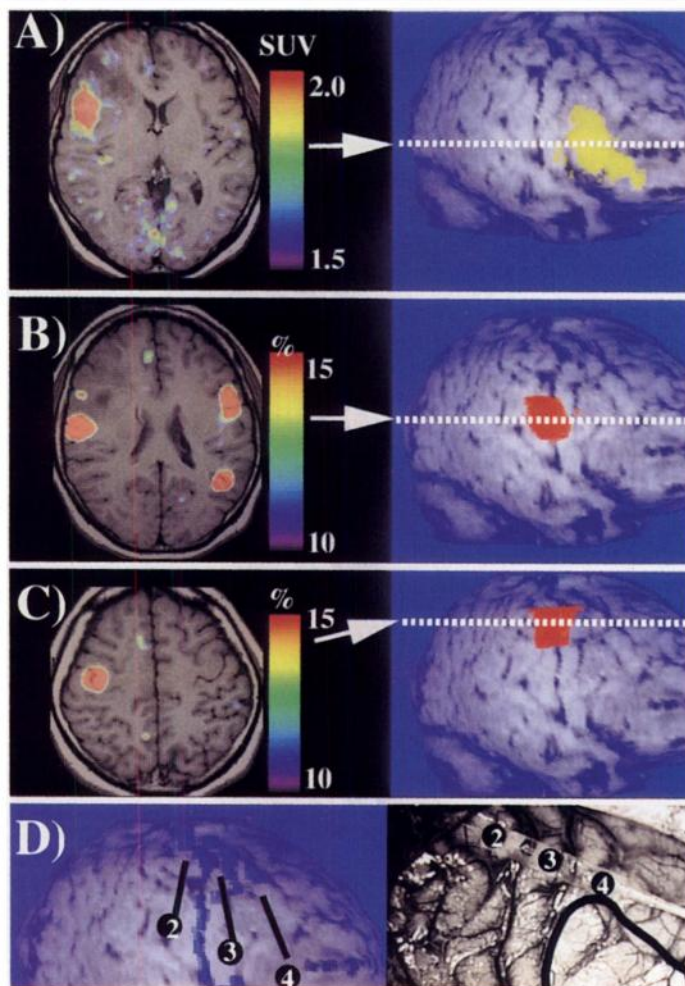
A 30-yr-old woman with right frontal astrocytoma (Patient 3). (A) The tumor area is defined as pixels that exceed 2.0 (SUV) in ^{11}C -methionine uptake on the PET images and are superimposed in a three-dimensional surface image. (B, C) Pixels that show more than a 15% elevation of PET-measured CBF during oral movement and finger movement are superimposed, respectively. (D) The correspondence between the three-dimensional surface image and the intraoperative figure. The position of the electrode, which was used for the intraoperative recording of somatosensory-evoked potential (SEP) by median nerve stimulation (16), is numbered in both images. The most prominent SEP were recorded in this electrode position, and it indicated that central sulcus existed between Electrode 2 and 3. Note that the center of the PET activation focus by finger movement corresponds well to this spot.
